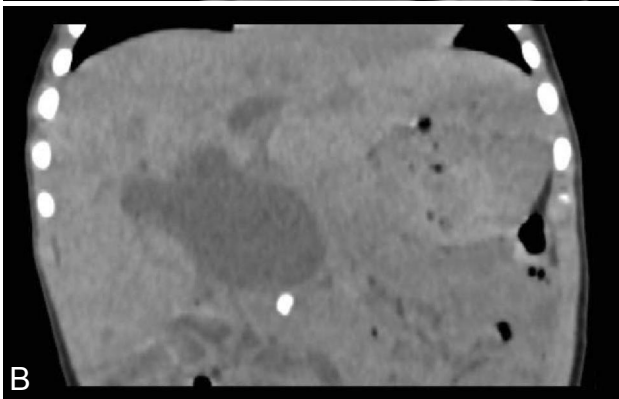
Choledochal cyst and choledocholithiasis in a 13 year old boy: A: Contrast enhanced sagittal CT section demonstrates a well-defined, thin walled cyst in the portahepatis (Choledochal cyst) with a hyperdense focus distal to it (choledocholithiasis). B: 24 hour delayed non-enhanced coronal CT section demonstrates the calculus.
